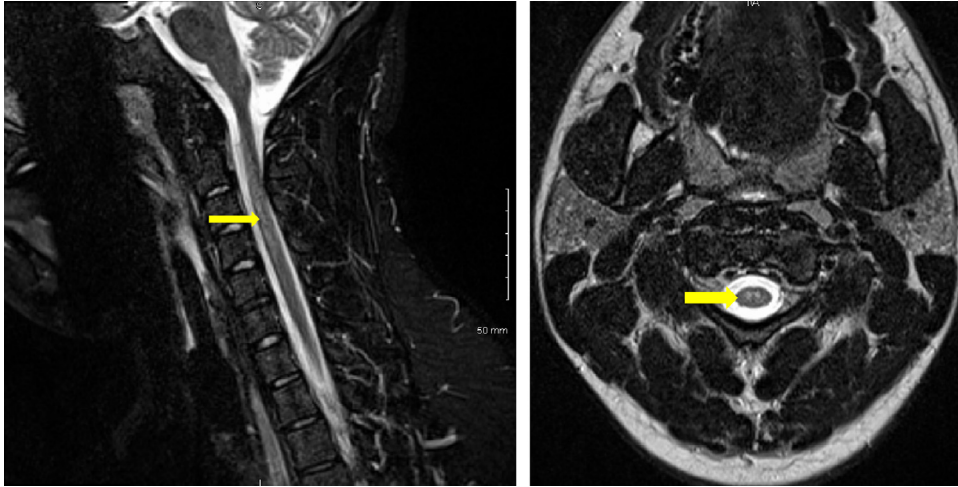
MRI of cervical spine with intravenous contrast done on admission with cord enhancement and possible hemorrhage indicated by the arrow.
